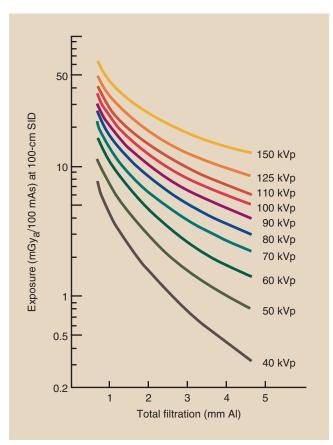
This family of curves is a nomogram for estimating output x-ray intensity from a single-phase radiographic unit. (Courtesy John R. Cameron,† University of Wisconsin.)
